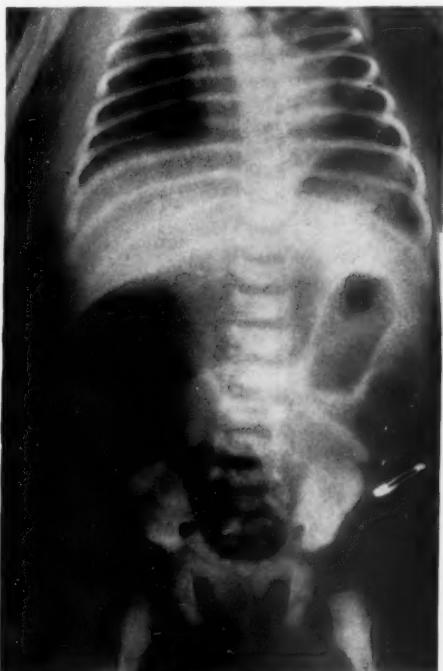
(Case 2.) Flat roentgenogram showing the dilated loops of small intestine above the site of obstruction.
